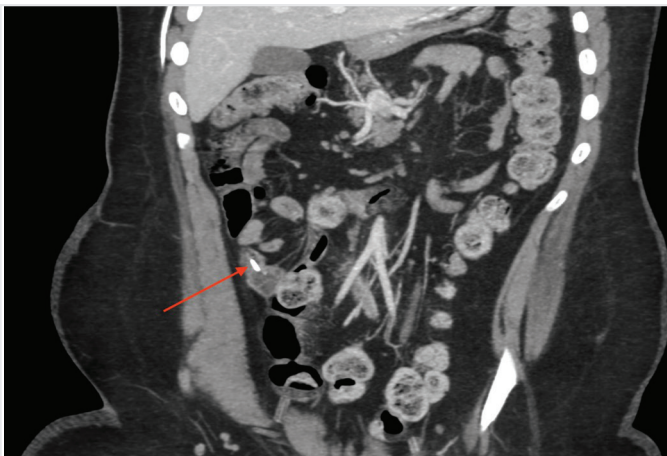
Ventriculoperitoneal shunt catheter appears to be in the terminal ileum in the coronal reformatted abdominal CT
